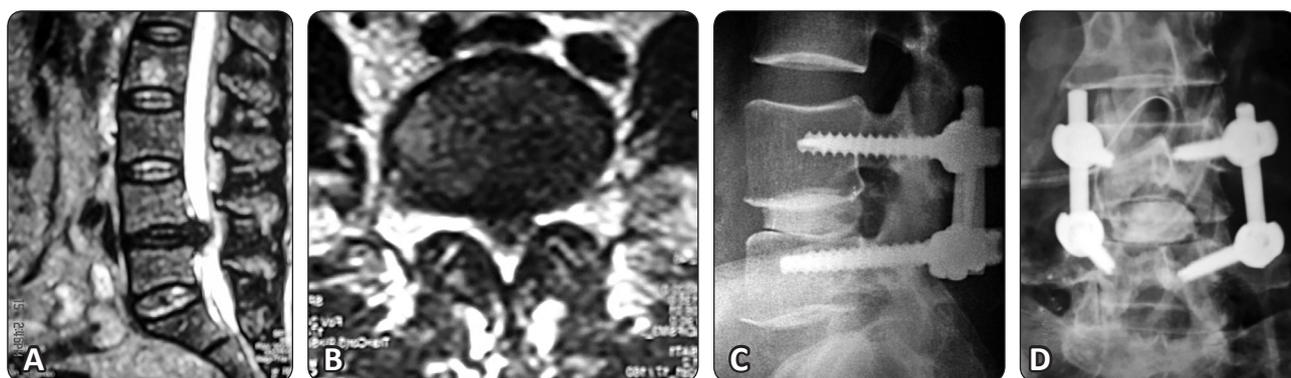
(A,B) Preoperative sagittal and axial MRI images showing L4-L5 disc prolapse, disc degeneration and lumbar canal stenosis. (C,D) AP and lateral X-rays immediate postoperative period. (E,F) AP and lateral X-rays of the same patient after 2 years follow up.
